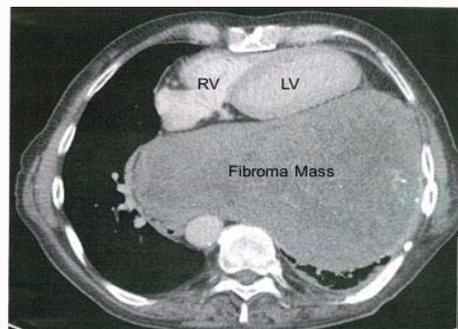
CT scan of chest in 2016 showing massive 20 cm size left sided mass compressing the heart and mediastinal shift to right, Right Ventricle (RV), Left Ventricle (LV).
